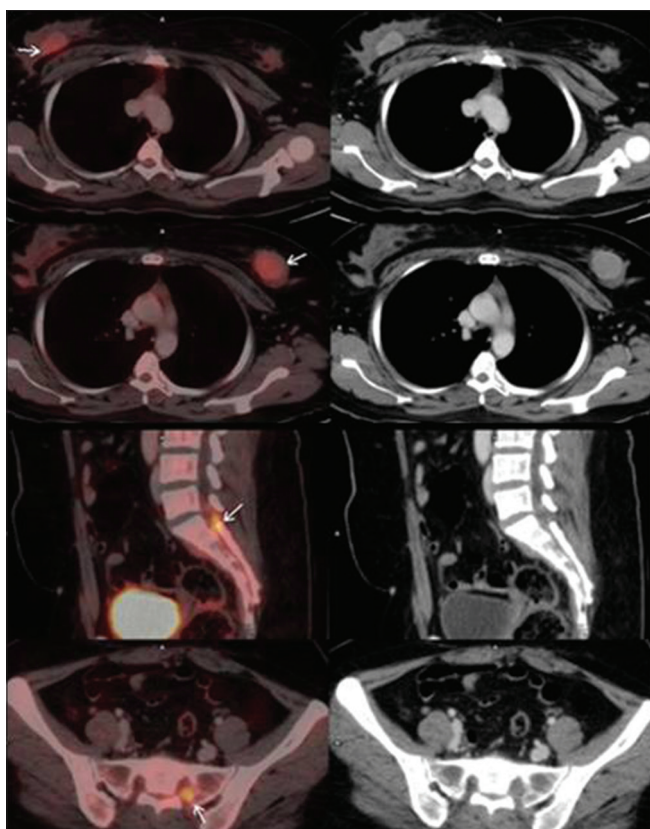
Positron emission tomography/computed tomography images showing fluorodeoxyglucose-avid deposits in bilateral breasts and ill-defined soft-tissue thickening in spinal canal at S1 vertebral level extending into 1st left sacral neural foramen
